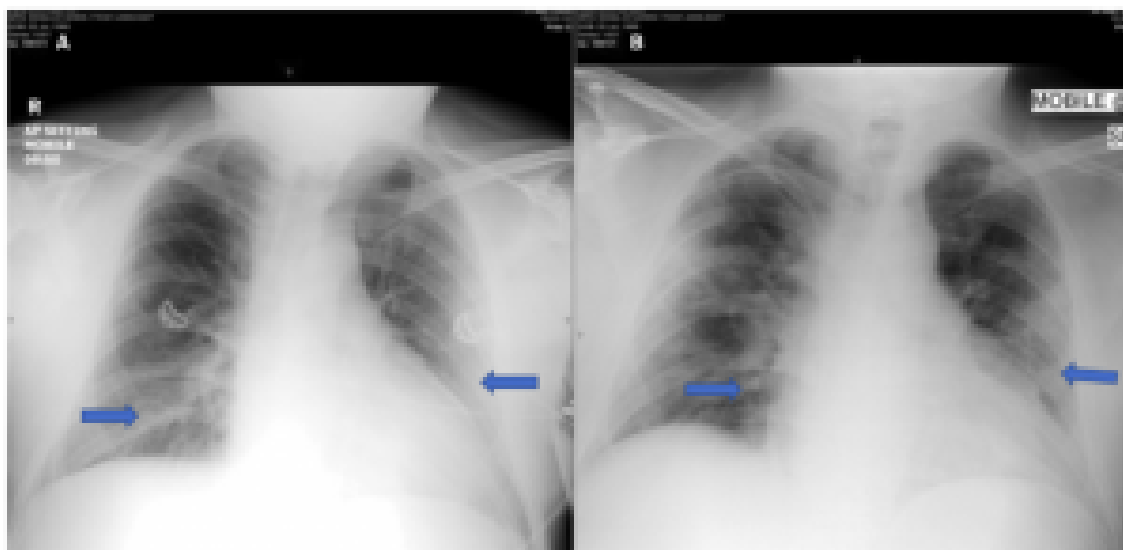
A – Chest X-ray on 17 March – bilateral infiltration (blue arrows) in the lower zone of lung. B – Chest X-ray on 20 March showed progressive bilateral infiltration in the lower zone.¹
